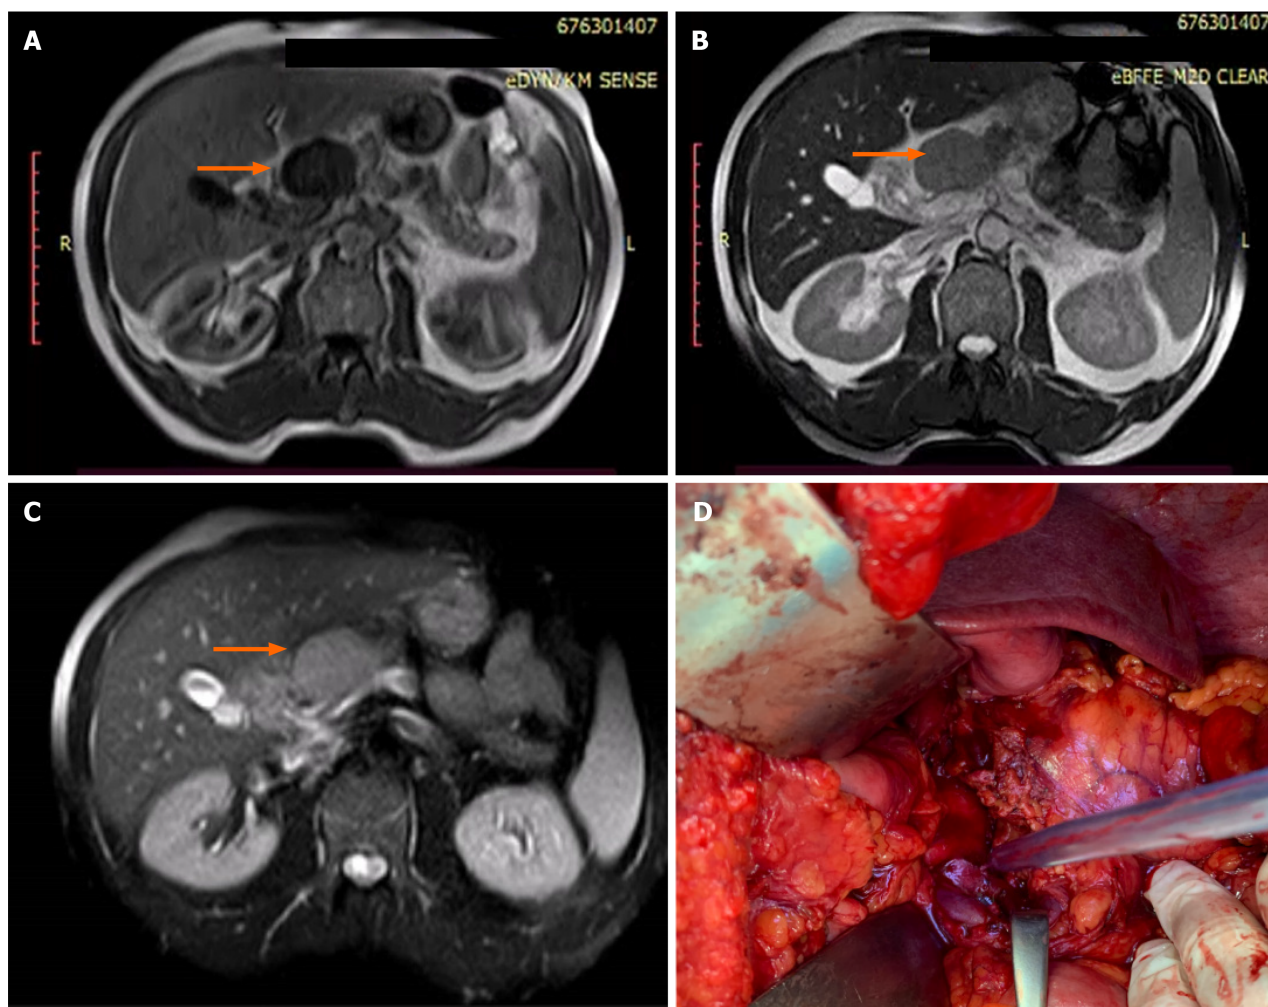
Magnetic resonance imaging and intraoperative finding of primary pancreatic lymphoma. A: T1-weighted magnetic resonance imaging (MRI) revealed a well-circumscribed, oval, hypointense lesion (58 mm in diameter) located in the neck and body region; B: Lesion was hyperintense on the T2-weighted MRI; C: Slight post-contrast MRI enhancement; D: Intraoperative finding after resection of the pancreas.
